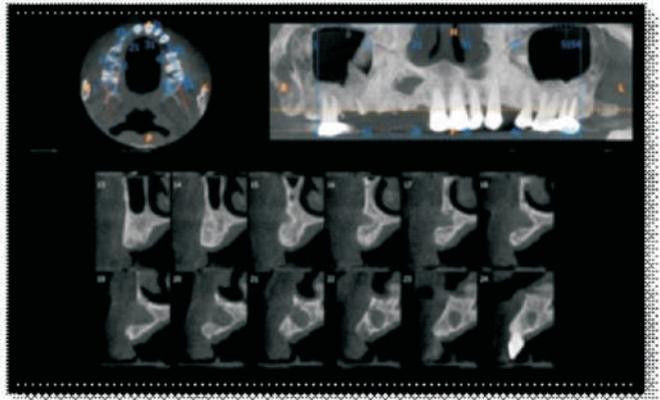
CBCT after the extraction
